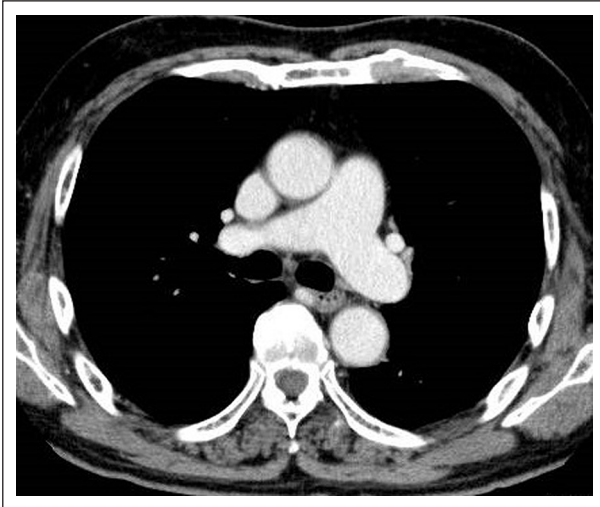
A contrast-enhanced computed tomography (CT) image obtained 1 month before the detection of the thrombus showed no abnormalities in the ascending aorta.
